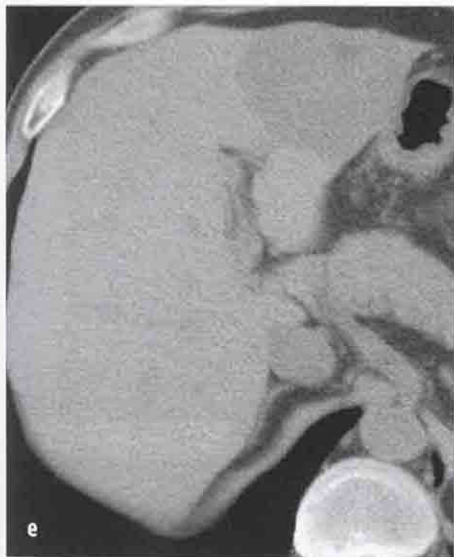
Hemangioma.* At baseline US, the lesion has atypical features and appears as an iso-hypoechoic nodule (a). At contrast-enhanced US, the lesion shows peripheral nodular enhancement in the arterial phase (b) with centripetal filling in the portal-venous and delayed phases (c, d). The enhancement pattern resembles that observed at multidetector CT (e, baseline; f, arterial phase; g, portal-venous phase; h, delayed phase)
